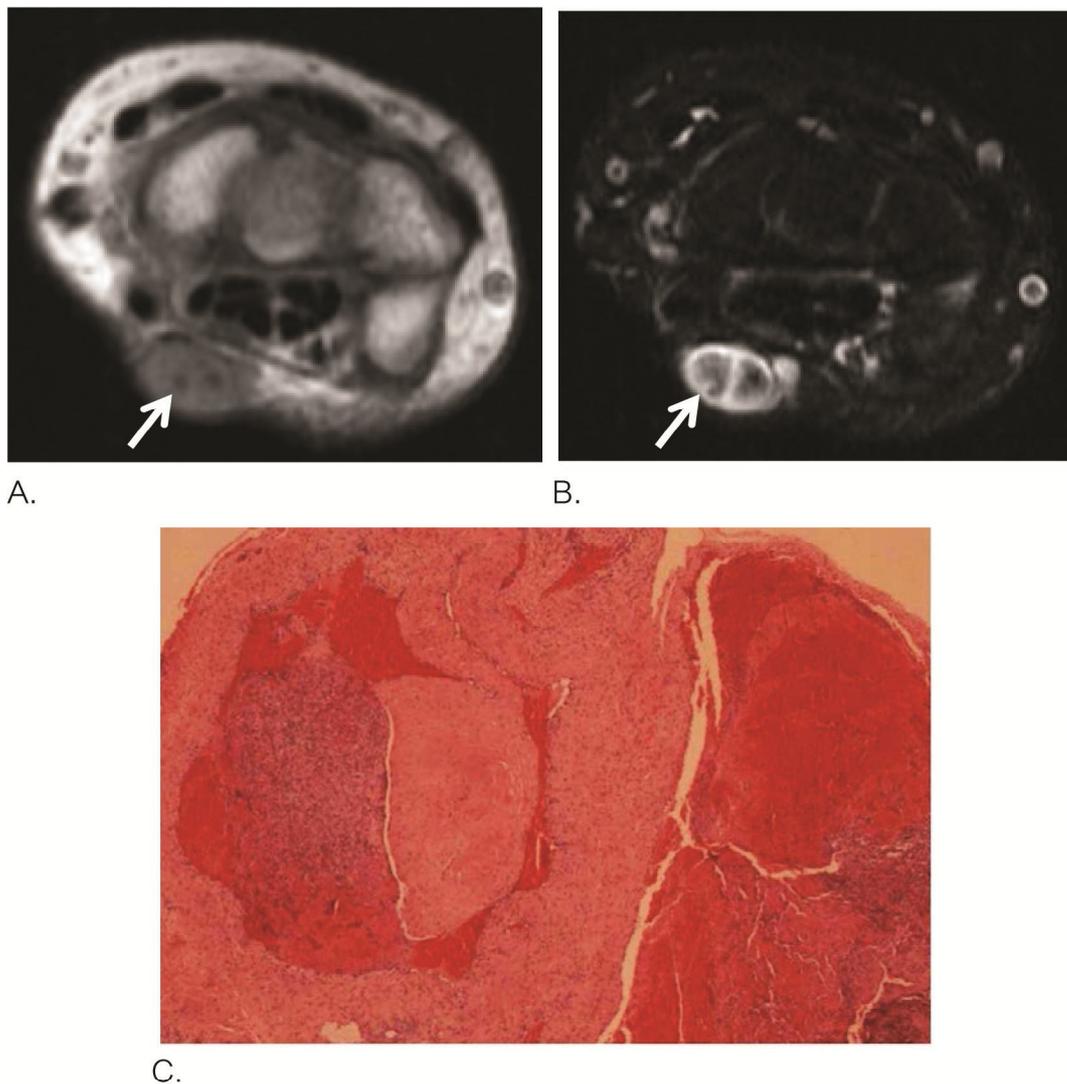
MR imaging of the left wrist of a 41-year old woman. Focal round hypointense areas on axial T1-weighted image A.) and axial STIR image B.) represent phleboliths (arrows). C.) The pathological diagnosis is venous malformation.
